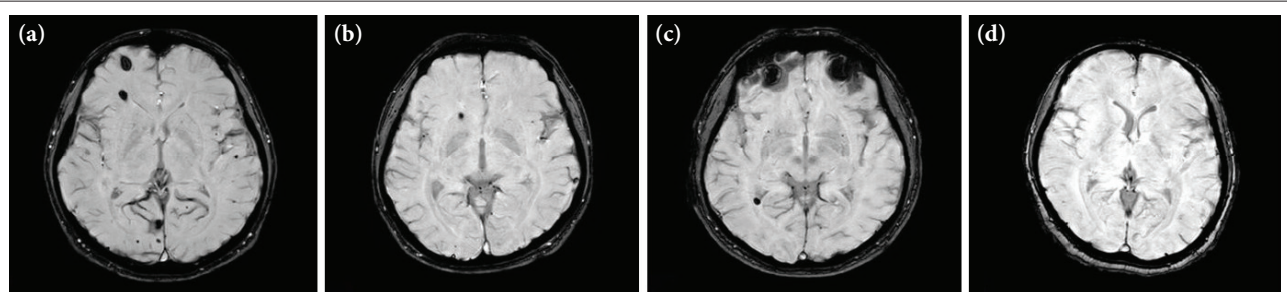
Axial hemispheric imaging. (a) Index patient's SWI sequence MRI. (b) Patient's brother's SWI sequence MRI. (c) Patient's father's SWI sequence MRI. (d) Patient's mother's normal MRI.
